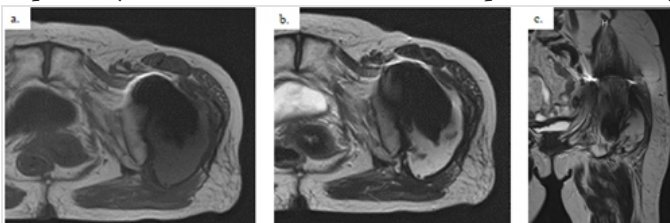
Findings of magnetic resonance imaging. (a) Horizontal section in T1 weighted image (T1WI): There is a space-occupying lesion that shows a huge fluid collection. (b) Horizontal section in T2 weighted image (T2WI): The periphery of the pseudotumor has a cystic structure, and the contents have a mosaic pattern. (c) Coronal section in T2WI: The cystic lesion is expanding in a multi-directional manner.
